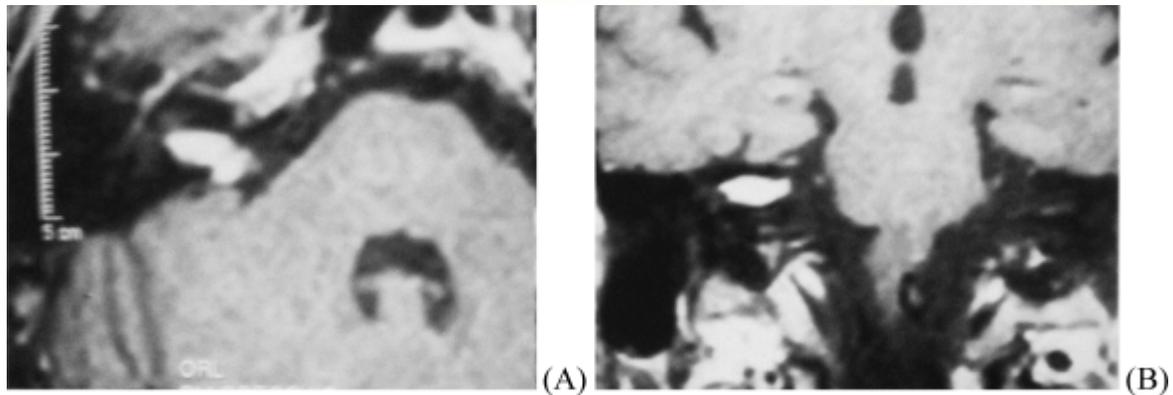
Gadolinium enhanced T1 weighted MRI (A: axial, B: coronal) done in 2001 that shows a one cm VS in the right CPA.
